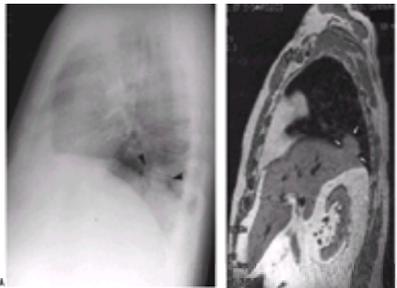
A: A lateral chest radiograph demonstrating an approximately 2-cm rounded opacity (*black arrowheads*) adjacent to the right hemidiaphragm. Because the inferior margin of the lesion was silhouetted by the diaphragm, it was suspected that the abnormality originated from or below the diaphragm. B: A sagittal MRI of the chest shows the liver (*white arrowheads*) herniating through the diaphragm.
